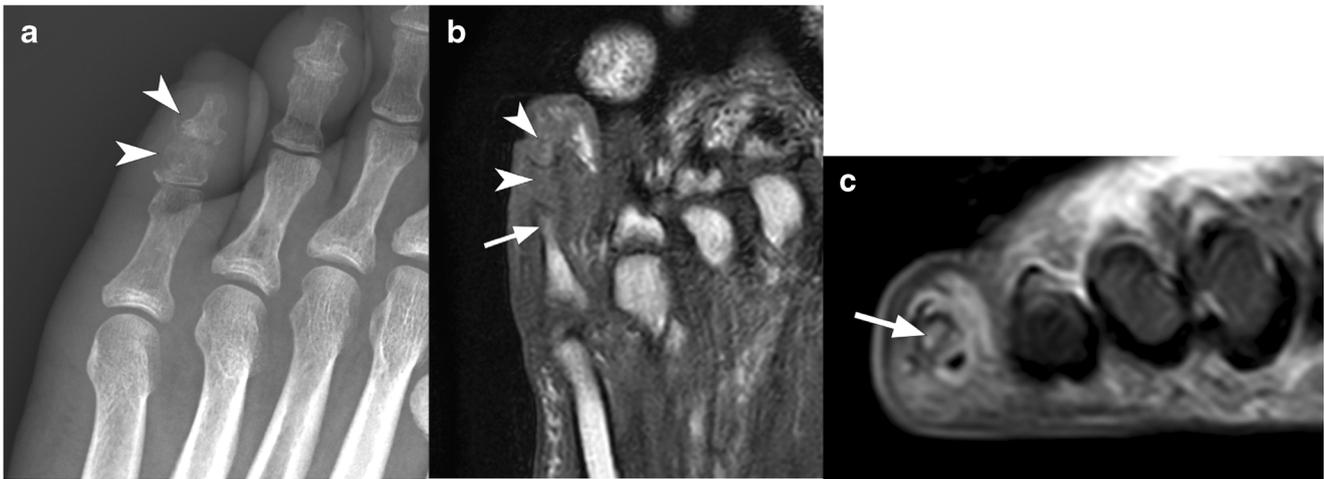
Example of an “MRI no-added value” case. A 69-year-old diabetic man with a nonhealing ulcer overlying the fifth distal interphalangeal joint. a Frontal radiographic projection demonstrated cortical erosion and rarefaction at the lateral aspect of the middle and distal phalanges of the fifth toe (*arrowheads*), with the radiological report stating osteomyelitis in these two bone segments. b Axial T1-weighted and c coronal STIR sequences from MRI obtained the next day show marrow replacement and edema in the distal and middle phalanges, but also involving the head of the proximal phalanx (*arrows*), with the MRI report stating
